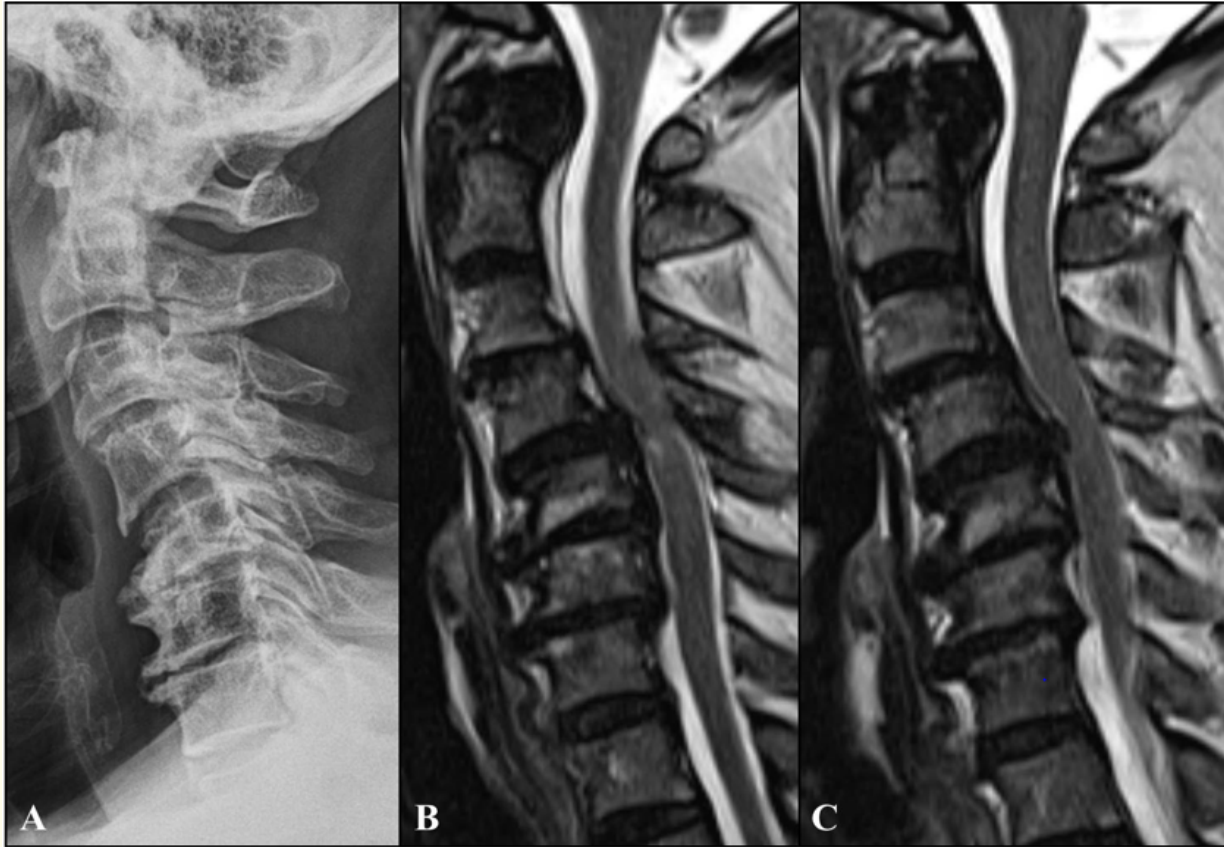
Preoperative lateral cervical plain radiography revealing a narrowed intervertebral disc space and kyphosis (A), and sagittal T2-weighted MRI of the cervical spine (B), (C). No evidence of ligament flavum buckling is seen.
